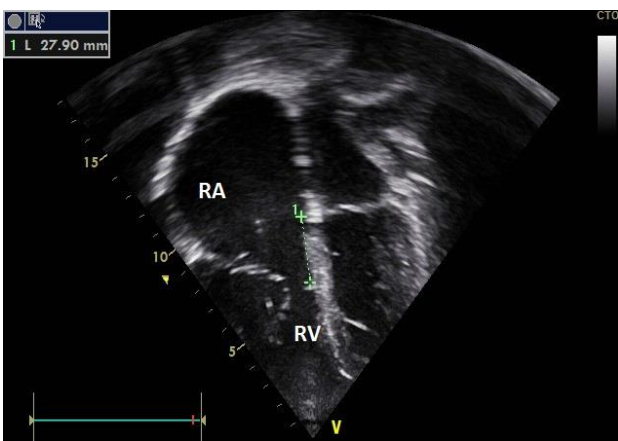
Echocardiography: Four chamber view. Apical displacement of the septal leaflet of tricuspid valve (27.9 mm). RA (right atrium), RV (right ventricle).
